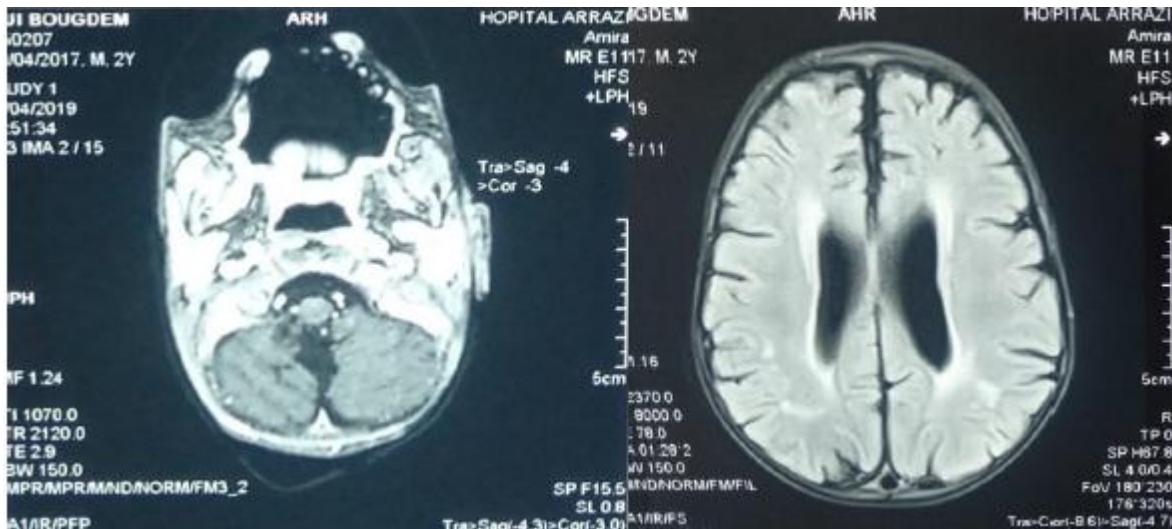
Multiple periventricular and cerebellar hypersignals on MRI.
